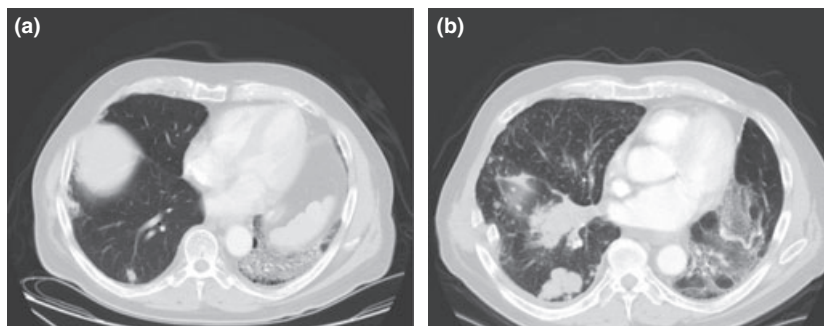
(a) August 30, 2005, chest CT, small nodule RLL. (b) March 3, 2006 – extensive metastatic disease with of right lung pulmonary masses and lymphangitic spread of tumor within the lung.
